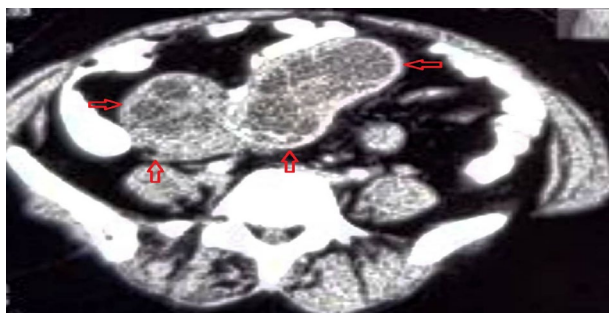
Involvement of left adnexa in CT scan imaging
